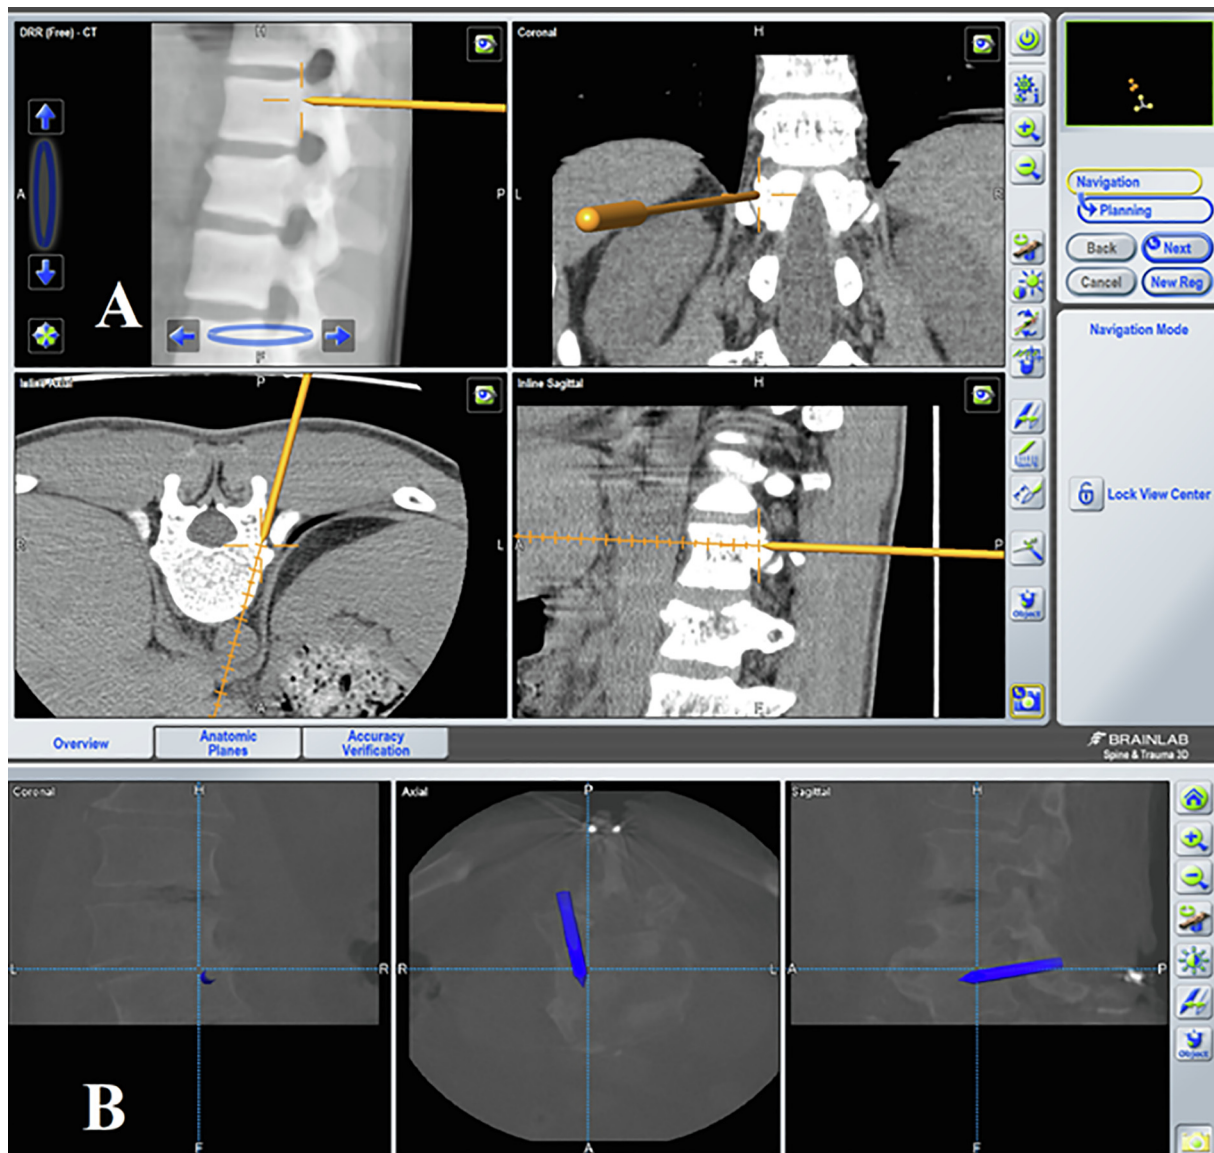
Sagittal, coronal, and axial CT scan reconstruction. (A) Screw's virtual extension in red as a roadmap, the trajectory of the trocar in yellow (B).
